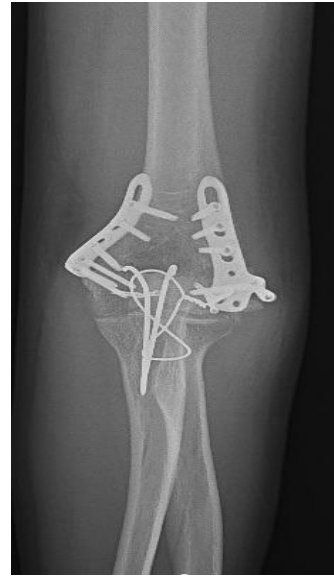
X-ray at final follow up
